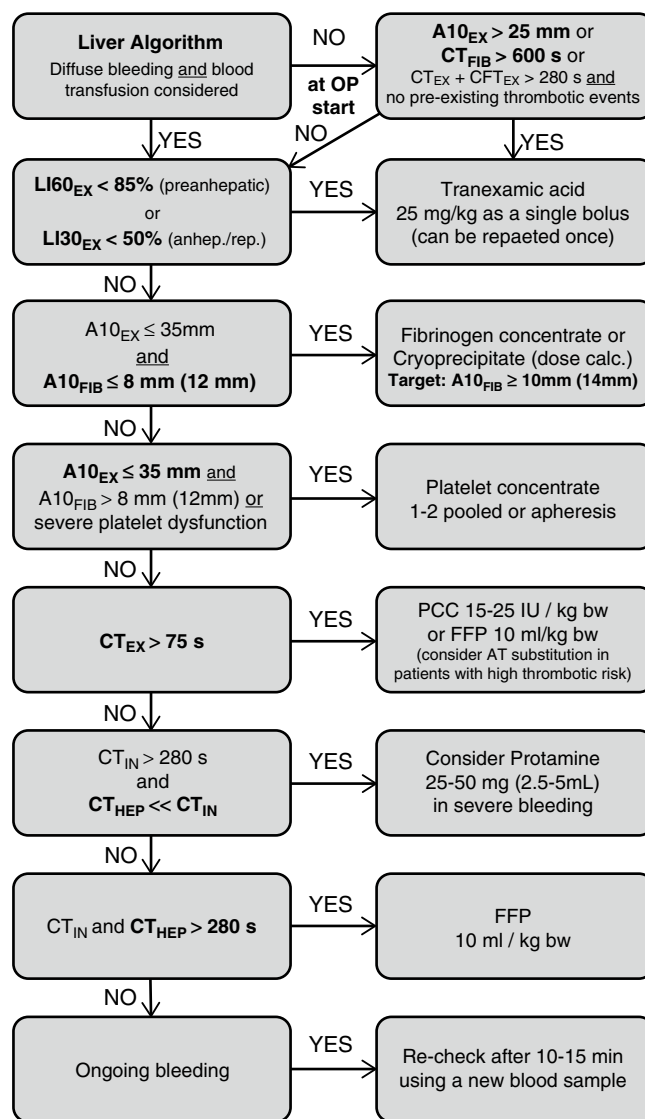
Evidence-based ROTEM™ A10 bleeding management algorithm in liver transplantation. $A10_{EX}$ amplitude of clot firmness 10 min after CT in EXTEM; $A10_{FIB}$ amplitude of clot firmness 10 min after CT in FIBTEM; bw body weight in kg; CT_{EX} coagulation time in EXTEM; CT_{FIB} coagulation time in FIBTEM ($CT_{FIB} > 600$ s reflects a flat-line in FIBTEM); CT_{HEP} coagulation time in HEPTEM; CT_{IN} coagulation time in INTEM; *dose calc.* dose calculation; *FFP* fresh frozen plasma; *IU* international units; $LI30_{EX}$ ($LI60_{EX}$) lysis index described as remaining clot firmness in percentage of maximum clot firmness (MCF) 30 (60) minutes after CT; *PCC* 4-factor prothrombin complex concentrate. Courtesy of Klaus Görlinger, Tem International
